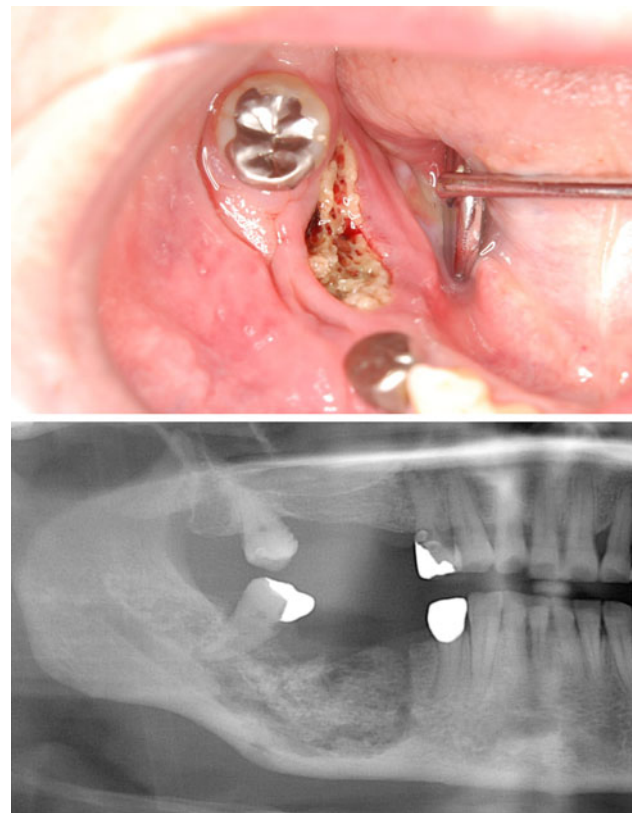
Macroscopic (*upper panel*) and radiographic (*lower panel*) views of representative bisphosphonate-related osteonecrosis of the jaws (BRONJ). Exposed necrotic bone is seen at the lingual side of the mandibular right second molar. A lesion with osteolysis and osteosclerosis extends from second molar to first premolar region on the panoramic radiograph
